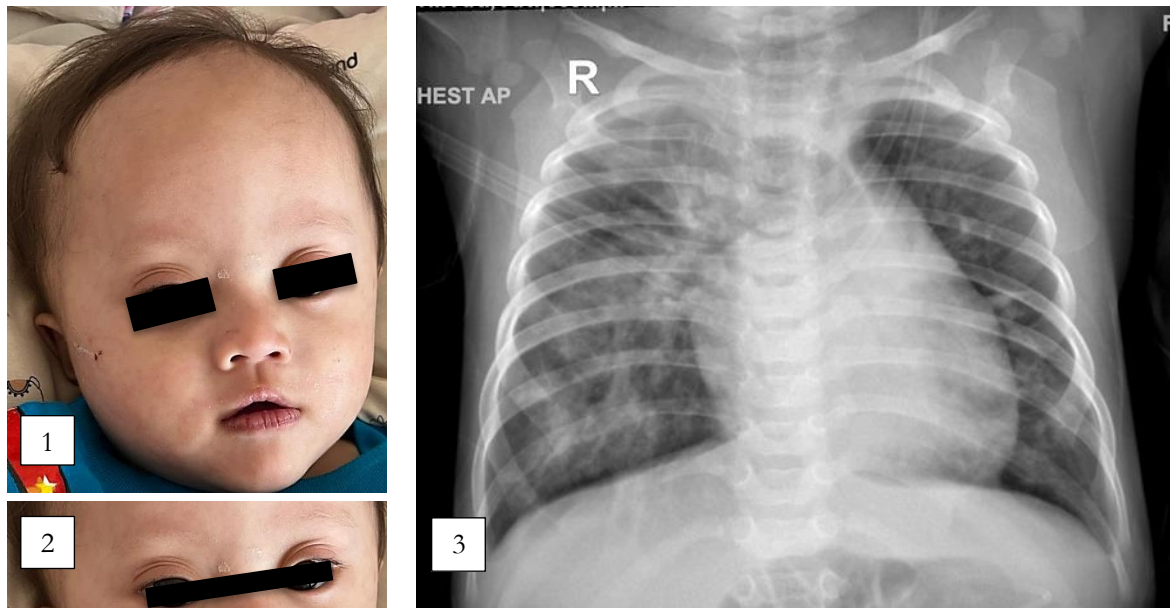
Mongoloid Face, 2. Epicanthal Fold, 3 Chest X-Ray PA (Source: Dwi,2024).
